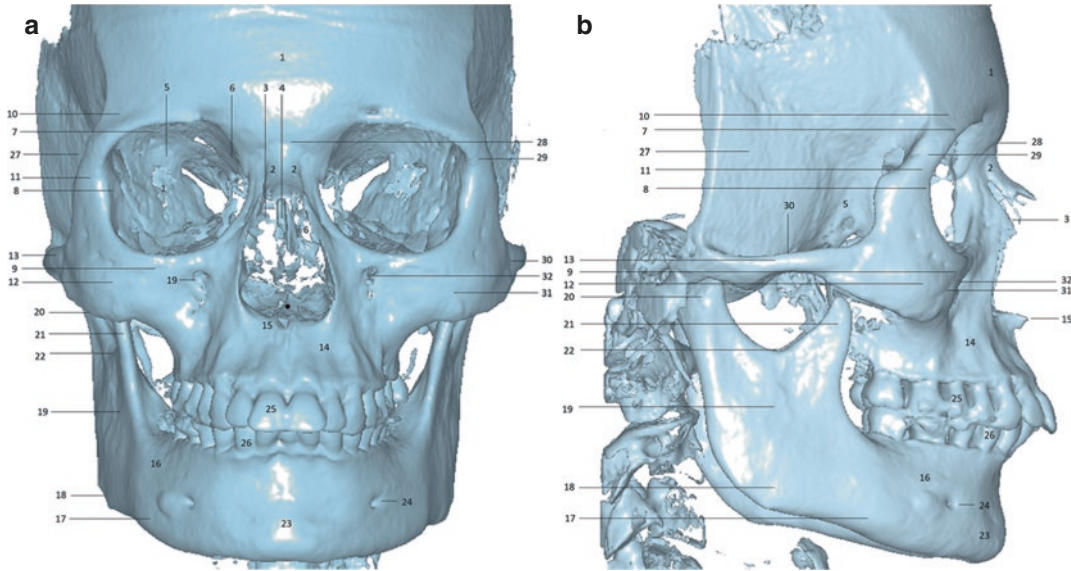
Three-dimensional cephalometric image created by CBCT together with the numbering of the most important anatomic parts: (a) frontal view and (b) lateral view.
